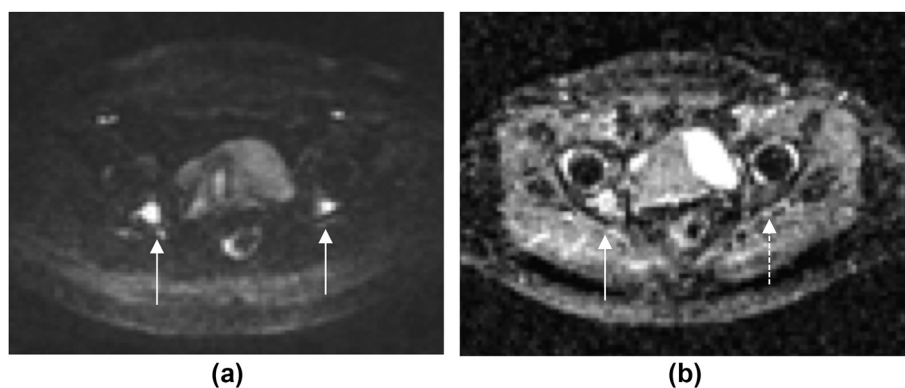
T2 shine-through. (a) Axial $b = 900 \text{ s/mm}^2$ DW-MRI of a patient with suspected relapsed myeloma shows bilateral acetabular lesions (arrows); (b) however, the corresponding ADC map shows that the lesion on the right returns a high ADC equivalent to fluid in the bladder confirming this to be an acellular treated lesion (arrow). The high signal on the $b = 900 \text{ s/mm}^2$ image represents T2 shine-through. Conversely, the lesion in the left acetabulum shows impeded diffusion in keeping with an active focal lesion (dashed arrow).
